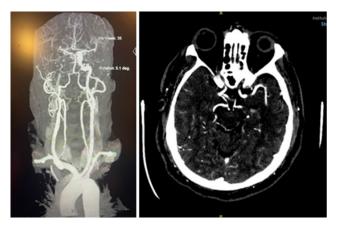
CT brain and neck angiogram: total occlusion of the right internal carotid artery (right image) and non- opacification of M1and M2 segments of right middle cerebral artery representing occlusion (left image).
